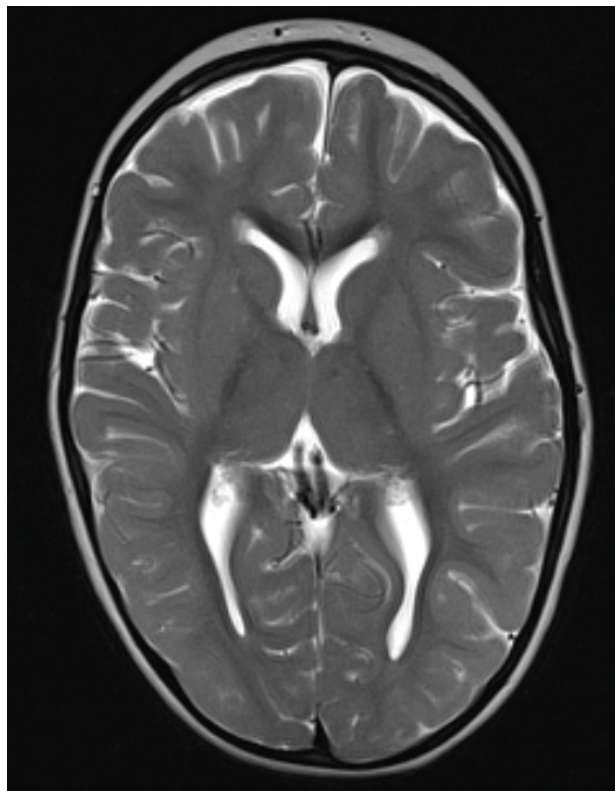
Brain MRI. Generalized retardation of the cerebral and cerebellar myelination, poor differentiation of the grey and white matter in a diffuse way and of the basal ganglia.
